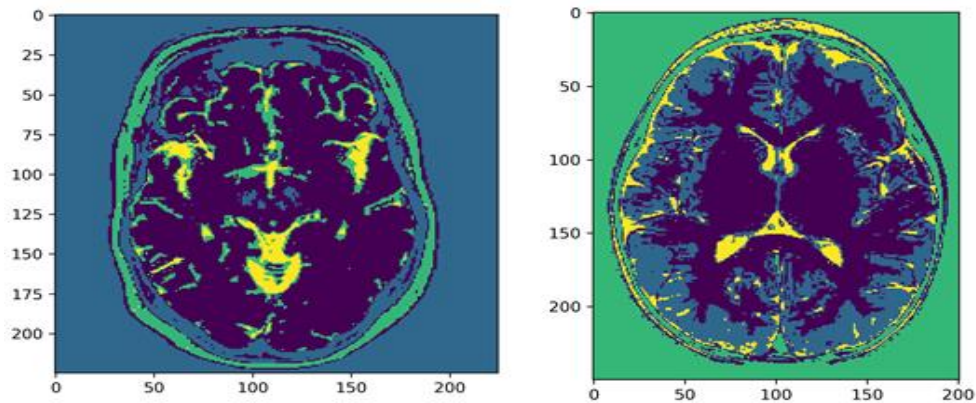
Sample Images for MRI Brain Tumour
